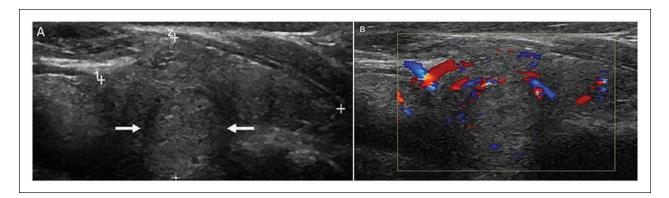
A sonogram that captures a benign thyroid nodule of the right lobe of the thyroid gland. (A) A sagittal sonographic view is provided of the right lobe of the thyroid and demonstrates a hyperechoic nodule, with a well-defined margin and lacking calcification (see white arrows). (B) A sagittal sonographic image of the right lobe of the thyroid, applied with color Doppler, and showing the peripheral vascularity of the right thyroid nodule. No internal vascular flow was noted.
